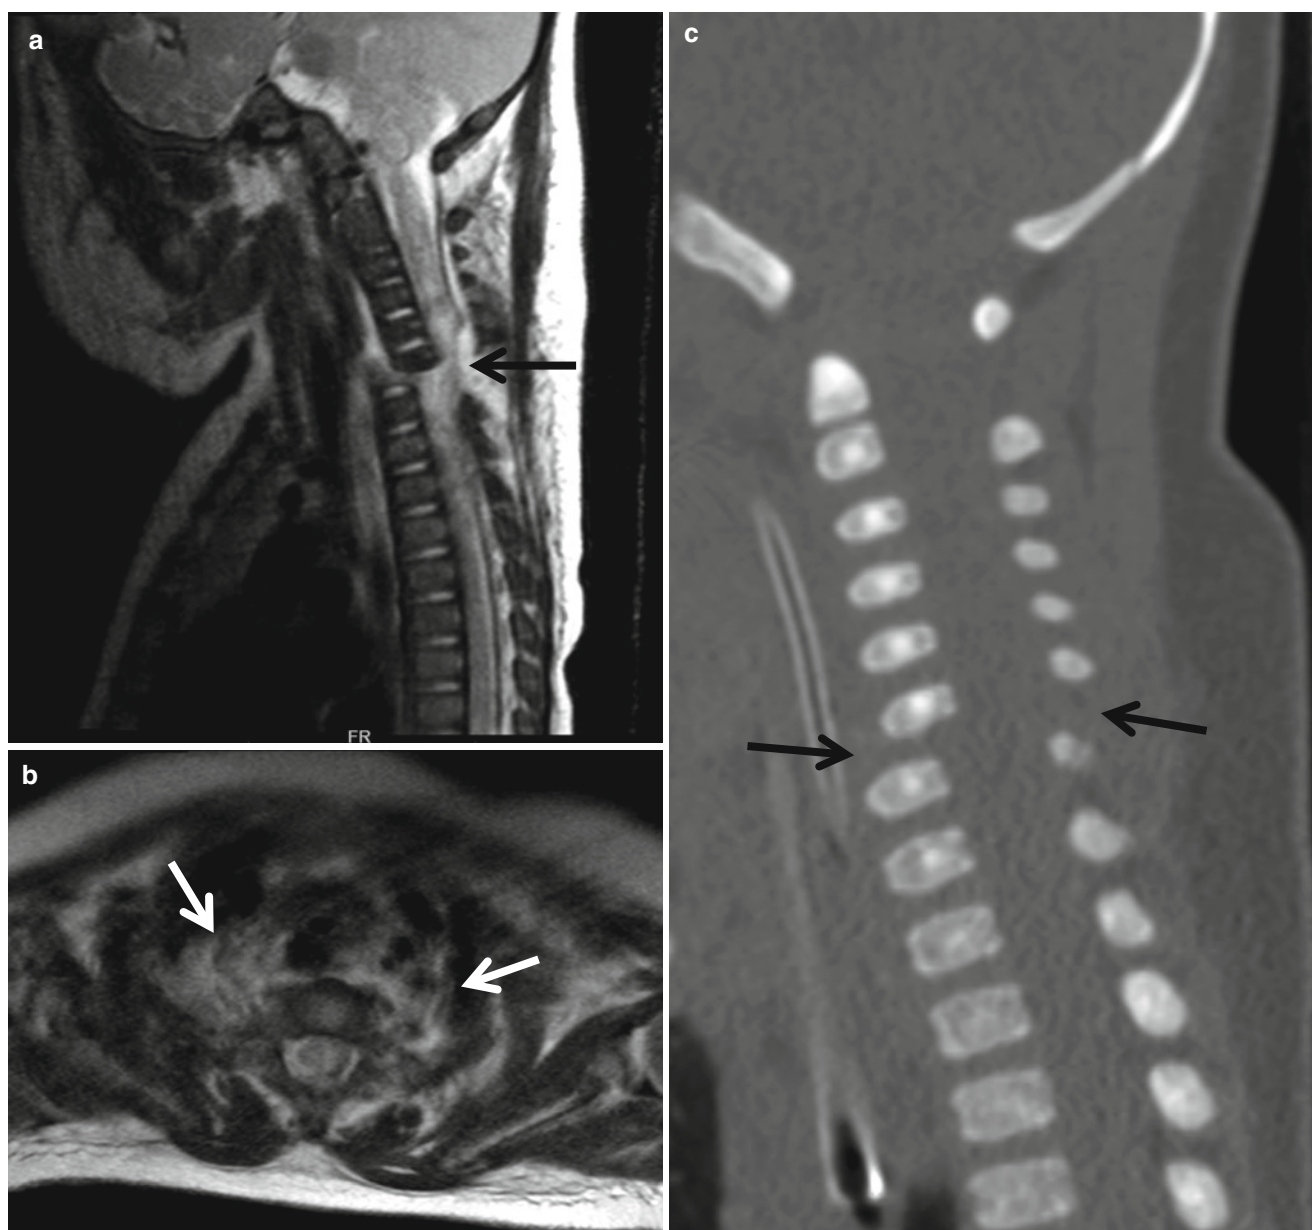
Spinal injury in a neonate with traffic accident. (a) T2-weighted sagittal image shows fracture dislocation of the C6–7 level with prevertebral edema. The cervical cord is compressed by the displaced fragment anteriorly and epidural hemorrhage posteriorly (arrow). (b) T2-weighted axial image shows increased signal intensity
